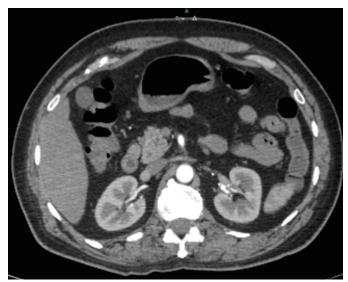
Computed tomography scan of abdomen showing normal kidneys.
